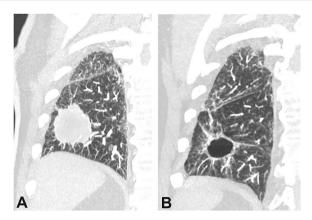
Computerized tomography (CT) scan with coronal view showing right lower lobe spiculated mass measuring $4.5 \times 4.6 \times 4.8$ cm (A). Diagnostic evaluation was consistent with pulmonary enteric adenocarcinoma. Repeat CT scan after therapy with carboplatin, pemetrexed, and pembrolizumab shows large cavity lesion where right lower lobe pulmonary enteric adenocarcinoma used to be. This lesion predominantly consists of an air cavity measuring $3.1 \times 3.5 \times 3.3$ cm.
